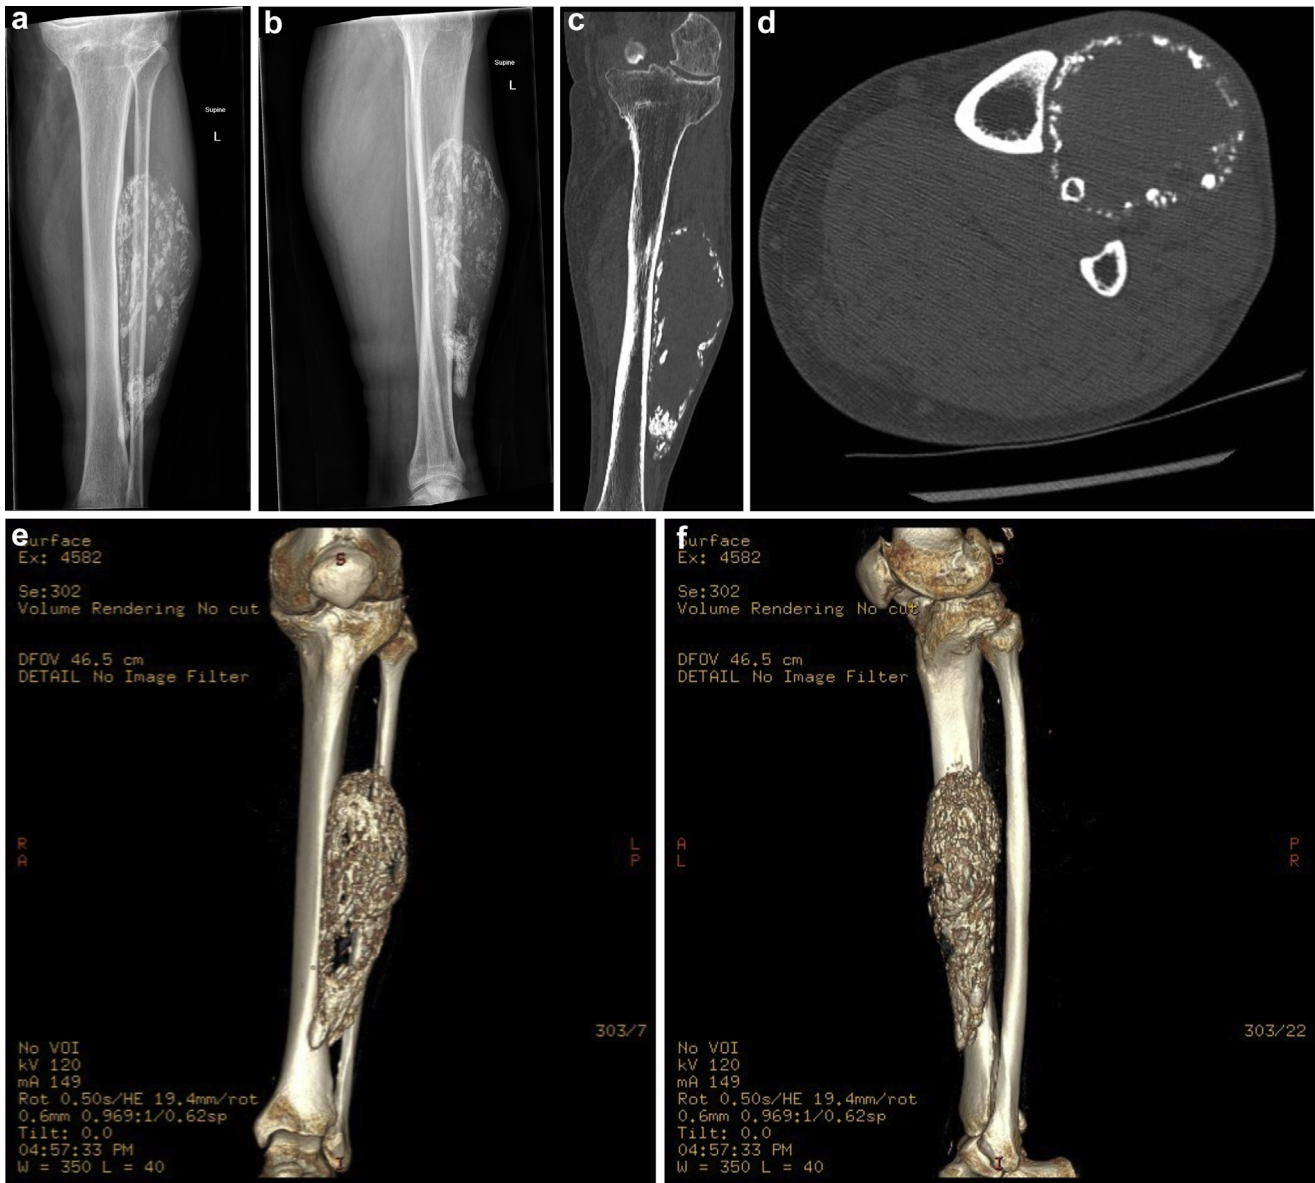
Radiographs and CT scan of patient's lower extremity to characterize mass. Anteroposterior (a) and lateral (b) tibia/fibula radiographs showing large anterior soft tissue mass with speckled calcifications. CT coronal (c) and axial (d) as well as 3-dimensional anteroposterior (e) and lateral (f) reconstruction views demonstrating anterior compartment mass with peripherally oriented amorphous calcifications, which are linear and sheet-like. The center is homogeneous.
